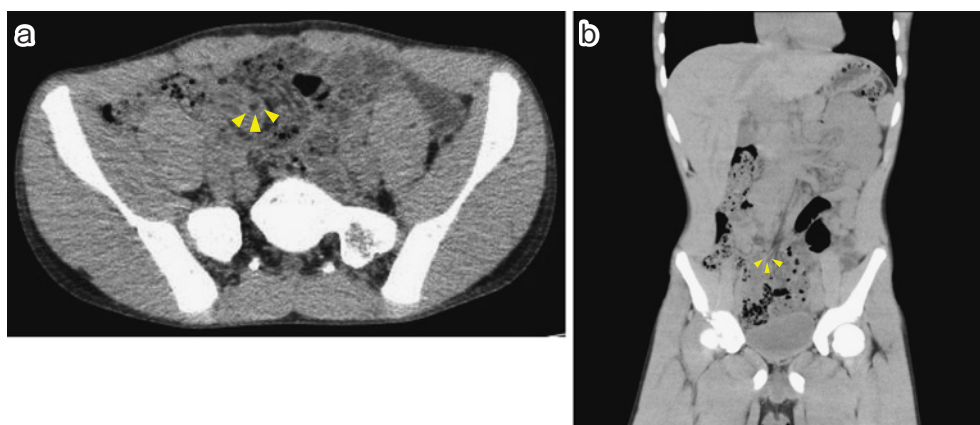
(a, b) Computed tomography showing the band that caused intestinal torsion
